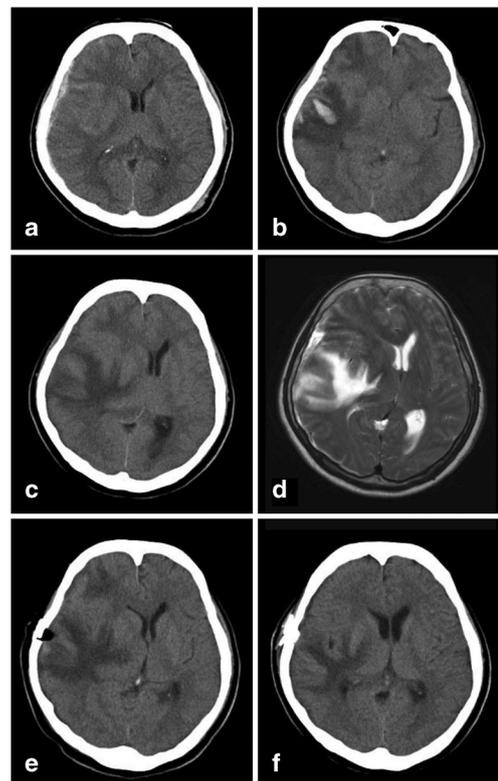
CT scans and MRI-T2 weighted image for case 2, a 58-year-old woman with fall accident from stairs. a CT scan on admission showing thin subdural hematoma in the right temporal region. b CT scan 1 day after trauma showing cerebral contusion in the right temporal lobe, conservatively managed because of the absence of neurological symptoms. c CT scan 10 days post-trauma after development of left hemiparesis showing increased contusional edema. d MRI-T2 weighted image showing fluid accumulation at the contusional lesion. e CT scan immediately after endoscopic aspiration of the contusion tissue. f CT scan 3 days after surgery showing marked decrease of the mass effect of cerebral contusion, with the intracranial pressure under 15 mmHg and improved hemiparesis
